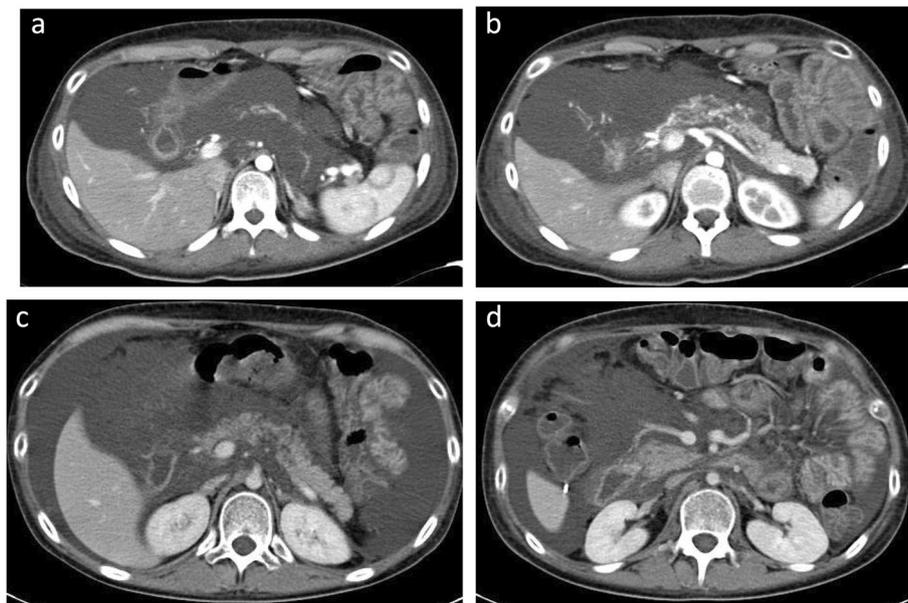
Enhanced CT findings of case 7. Case 7 enhanced CT finding with chylous ascites with PLGE. a, b CT findings before intralesional sclerotherapy using OK-432. c, d CT findings after intralesional sclerotherapy using OK-432
